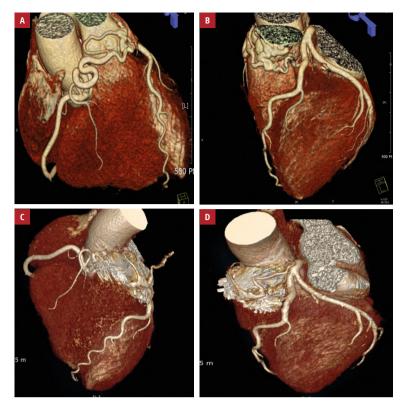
Cardiac computed tomography angiography showing: A – coronary arteriovenous (AV) fistulas from the right coronary artery ostium; B – multiple coronary AV fistulas communicating the left main coronary artery and the mid-left anterior descending artery with the main pulmonary artery (PA). After 9-year follow-up: C – no significant shunt flow from the right coronary artery to the PA; D – no significant shunt flow from the mid-left anterior descending artery to the PA and reduced shunt flow in the remaining small AV fistula from the left main coronary artery to the main PA
